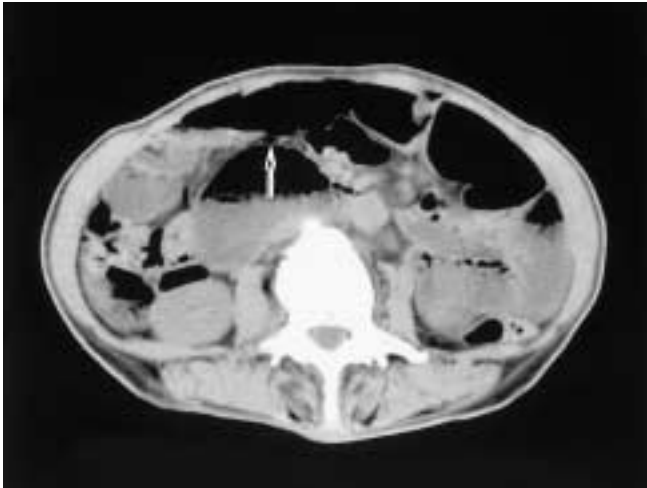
Computed tomography demonstrated extraluminal gas-filled lesions (arrows) in the small intestine.
